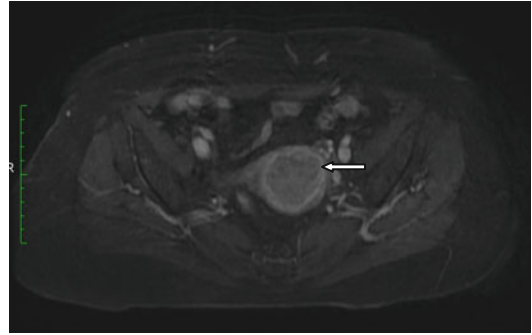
Post-contrast axial T1-weighted fat-suppressed image showing mass in the endometrial cavity surrounded by intact early and brightly enhancing junctional zone (*straight arrow*); early contrast phase allowing easy distinction of the endometrial mass from the junctional zone
